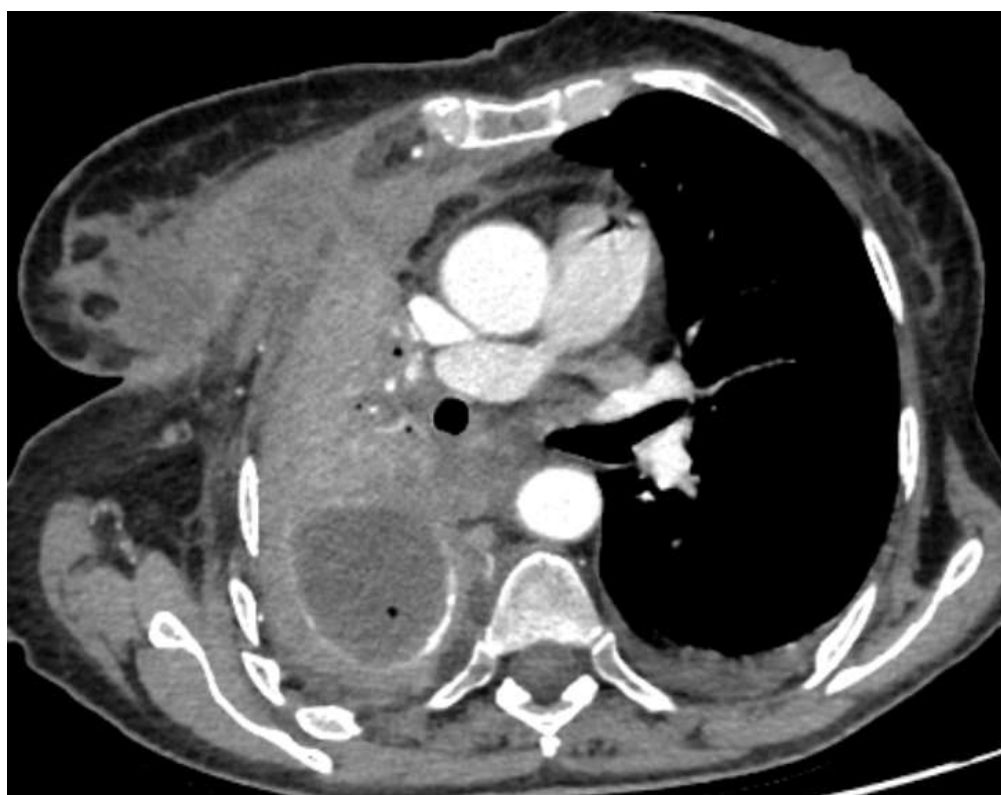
The chest CT scan showed a fistula tract from a right pleural residual collection extending to the skin with a right lung collapse.
